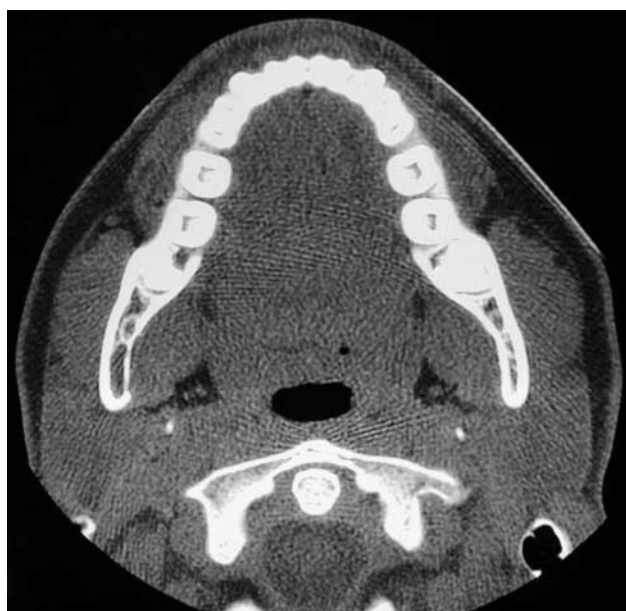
Two-dimensional CT axial view at the level of the ramus lesion showing a thinner lingual cortex in which there is no contact between the parotid gland and the lingual or buccal aspects of the ascending ramus
